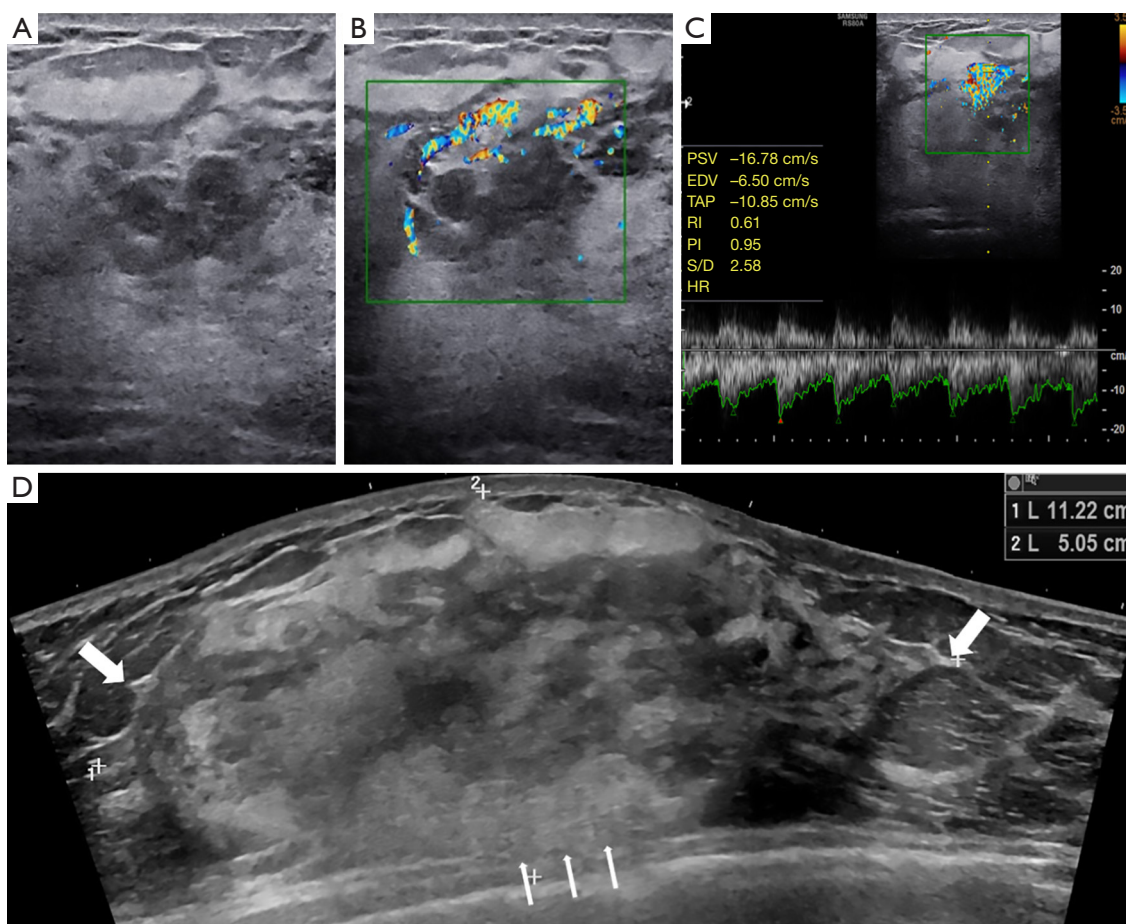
Ultrasonography of the giant breast angiosarcoma. (A) Routine ultrasonography shows a diffuse, mixed hyper- and hypoechoic region. (B) Color Doppler imaging reveals the hypervascular character. (C) Spectral Doppler imaging shows an arterial flow spectrum with PSV of 16.78 cm/s and RI values of 0.61. (D) EFOV ultrasound imaging shows a giant, hyper- and hypoechoic mass measuring approximately 112 mm × 50 mm that occupied almost the entire right breast. The mass shows angular margins (thick arrows) and invasion into adjacent tissues (thin arrows). EFOV, extended field-of-view; PSV, peak systolic velocity; EDV, end-diastolic velocity; TAP, time-averaged peak velocity; RI, resistance index; PI, pulsatility index; S/D, systolic/diastolic ratio; HR, heart rate.
